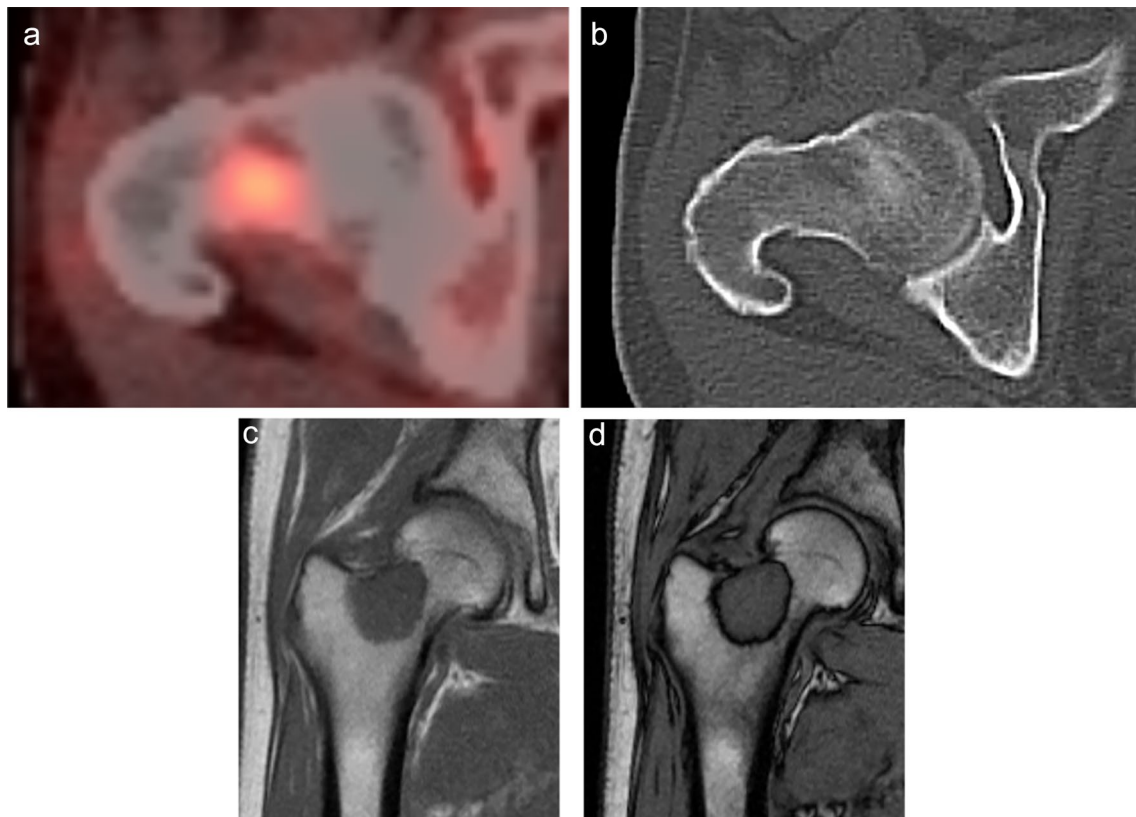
A 65-year-old male patient with a history of lung cancer. FDG-PET CT image a shows a focal hot spot in the right femur. CT finding is almost normal but maybe slightly osteoblastic in retrospective interpretation (b). SUV_{max} of the right femur lesion is 4.8.
